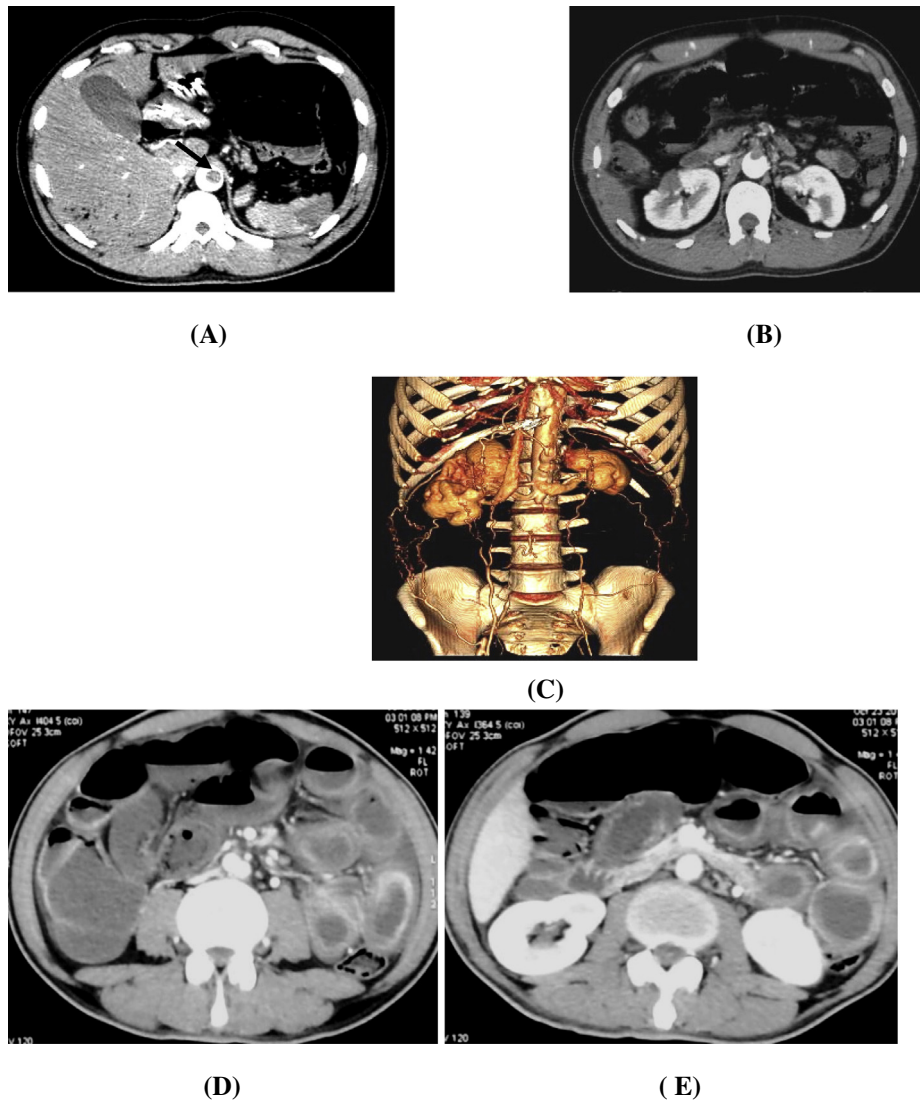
A 50 year old male patient with Leriche Syndrome. MDCT showed hypodense thrombus filling defect within abdominal aorta (A). Extension of thrombus to the origin of the SMA (B). 3D CT angiography revealed infra renal aortic occlusion with multiple dilated collaterals (C). Small bowel showed segmental symmetric moderate wall thickening with target appearance of enhancement (D and E).
